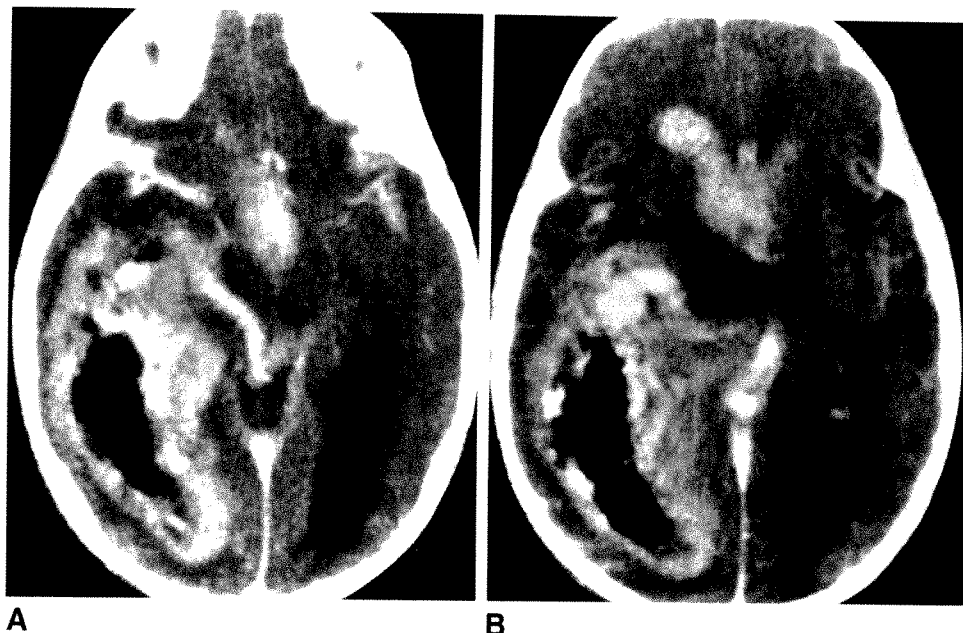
Case 4: 52-year-old woman. A and B, Pre- (A) and post- (B) gadolinium-DTPA MR images, 550/30 (0.5 T), reveal peripheral enhancement of intraventricular primary CNS neuroblastoma.
